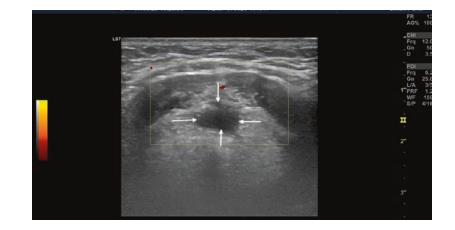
USG view of a ranula shows anechoic cystic lesion (white arrows) with smooth contours and without internal septa in the left sublingual region. No vascularization is noted on the color Doppler USG
